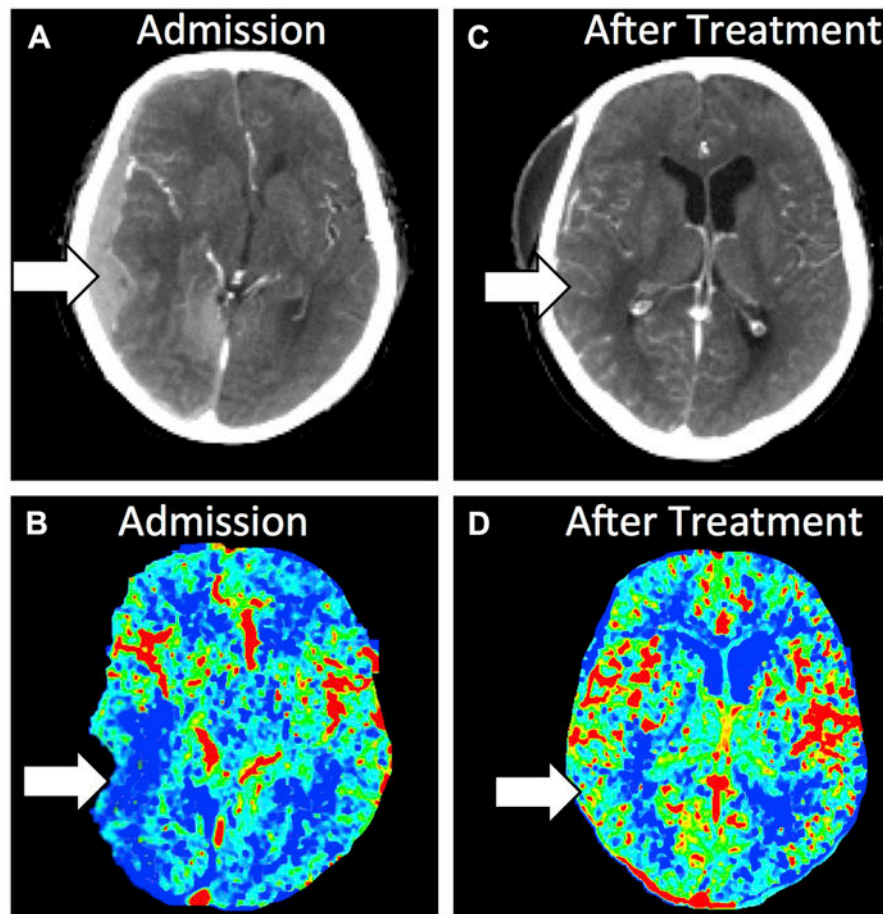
Contrast-enhanced and PCT images from a patient with severe TBI. (A) Contrast-enhanced CT imaging at admission demonstrates a right-sided subdural hematoma causing mass effect on the underlying brain and midline shift. (B) rCBF PCT imaging at admission demonstrates decreased rCBF in the right temporal lobe. (C) Contrast-enhanced CT image after surgical evacuation of the hematoma demonstrates resolution of the right-sided subdural hematoma, mass effect and midline shift. (D) rCBV PCT imaging after surgical evacuation of the right-sided hematoma demonstrates normalization of the rCBF in the right temporal lobe.
